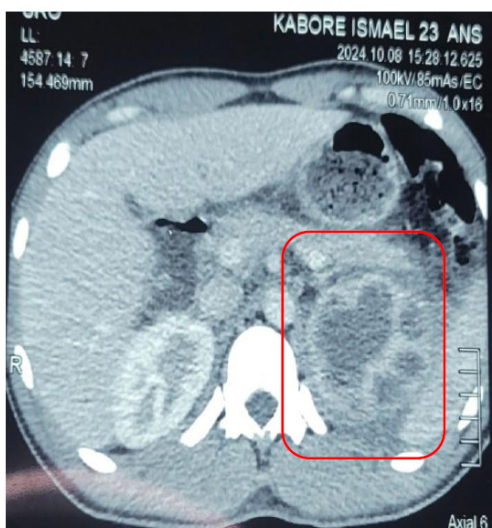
Frontal section of injected CT scan showing 'bear's paw sign' in orange frame
